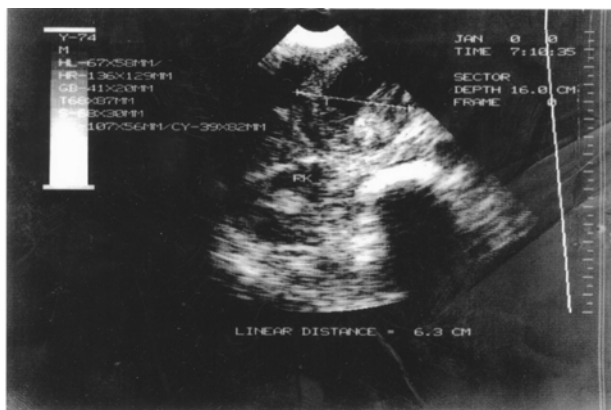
Case 3, female, 66 years old, the parenchymal type of carcinoma of gallbladder by ultrasonography
